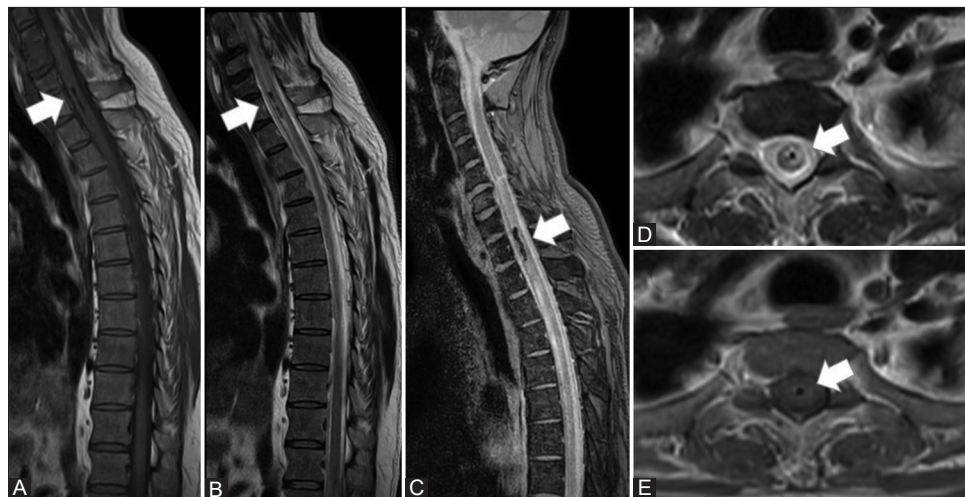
Panel A. Sagittal T1 weighted MRI image of the spinal cord showing a linear hypointensity at the C8-T1 level. Panel B. Sagittal T2 weighted MRI showing a linear hypointensity at C8-T1 level with extensive spinal cord edema. Panel C. STIR sequence sagittal MRI- hypointensity at C8-T1 level. Panel D and E. T2 and T1 weighted axial images showing a central cord lesion with surrounding edema
